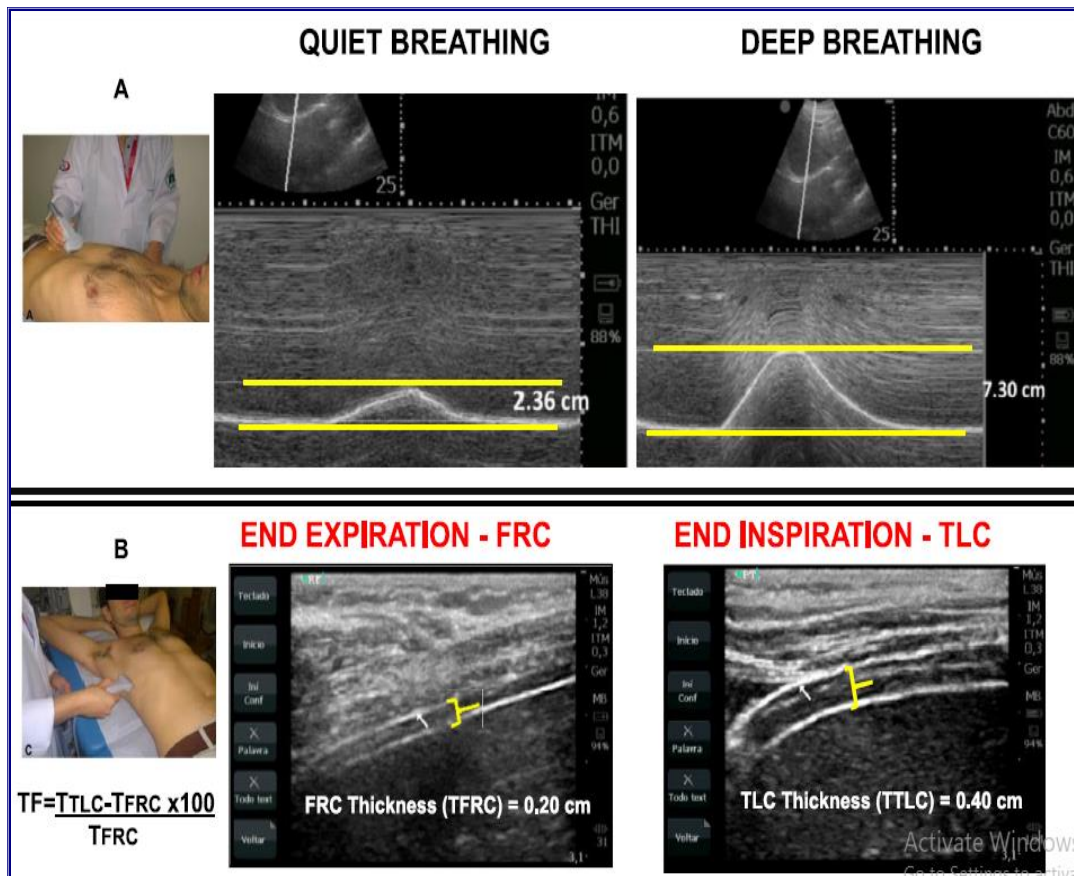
Ultrasound imaging of the diaphragm to measure mobility (a) during QB and DB, and thickness (b) at FRC and TLC. Thickening fraction was derived by the thickness obtained in both conditions. QB = quiet breathing; DB = deep breathing; FRC = functional residual capacity; TLC = total lung capacity³⁶.
